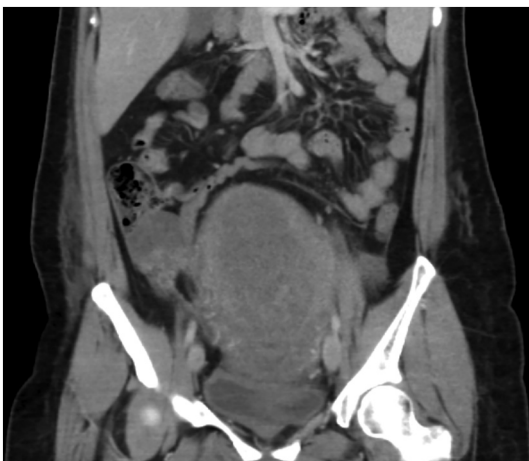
Abdominal computed tomography (CT) scan demonstrating a large soft-tissue mass distending the uterus.
